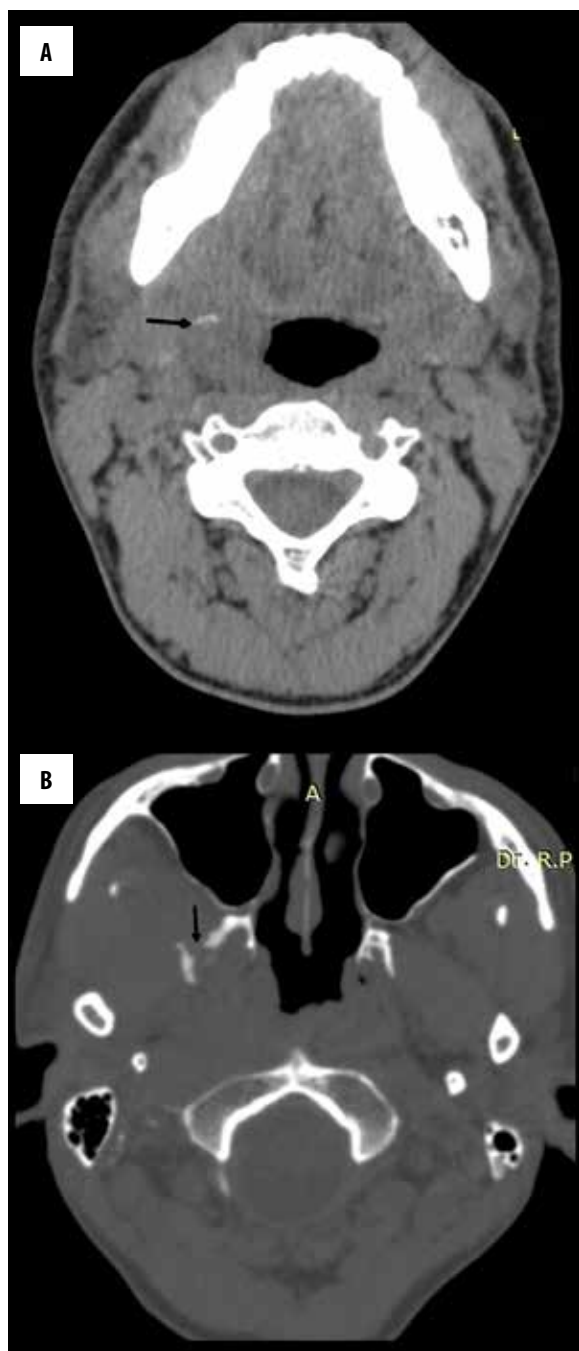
(A) Non-contrast axial CT (WW 350, WL 60) showing a hyper-dense foreign body in the right masticator space (arrow). (B) Axial and (C) coronal reformatted CT images (WW 1500, WL 300) showing a fracture of the right lateral pterygoid plate (vertical arrow). The fractured bony fragment is displaced laterally (horizontal arrow).
